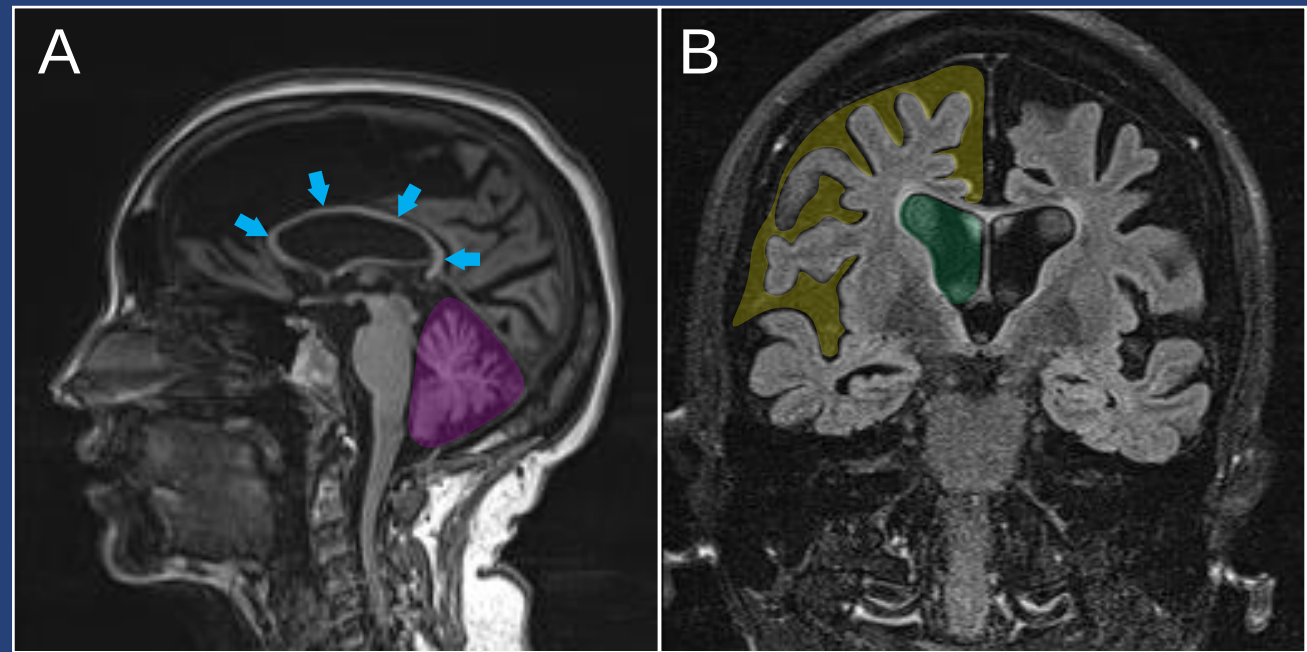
Sagittal (A) and coronal (B) T2-FLAIR MR images; (A) severe, diffuse corpus callosum thinning (blue arrows) and moderate cerebellar vermal atrophy (purple shading); (B) moderate bilateral cortical atrophy (yellow shading) and ventriculomegaly (green shading).
